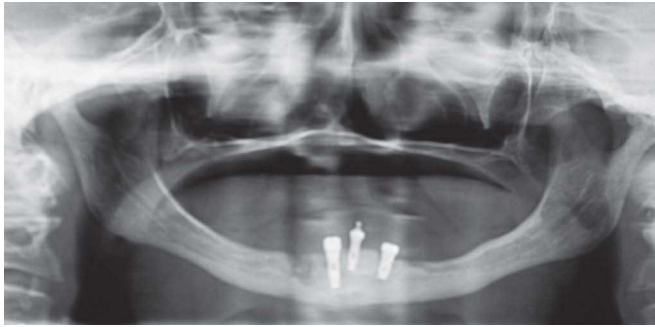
Panoramic radiograph revealing loss of implants, associated with bone rarefaction.
